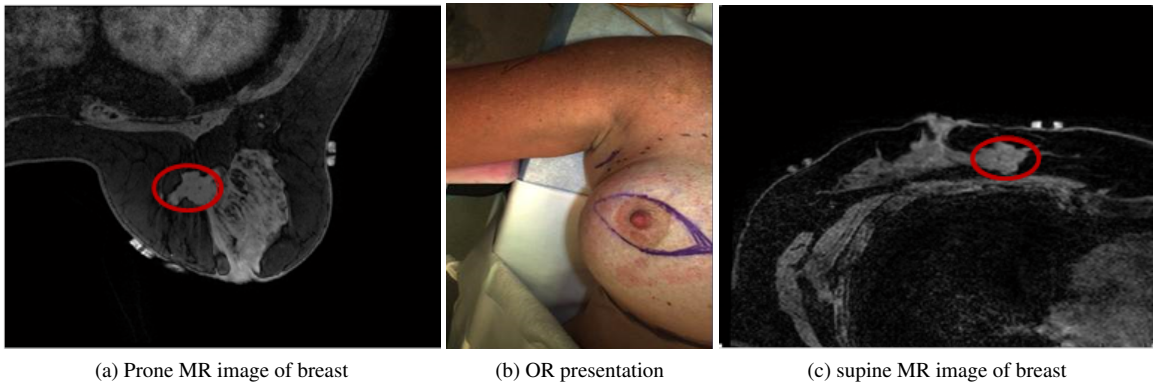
1: Demonstration of the challenge of using preoperative images for surgical guidance. (a) and (c) are axial slices of T_1 -weighted THRIVE sequence MR images in the prone and supine positions with red ovals designating the same tumor in the same axial slice. Changes in patient setup cause the tumor to move, yielding the diagnostic scan in (a) less valuable for locating the tumor in the surgical setup, shown in (b).
